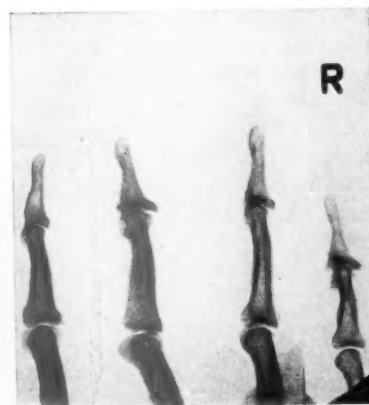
Lateral radiographs of the fingers shown in Fig. 2 show marked spur formation arising from the attachments of the flexor and extensor tendons.
